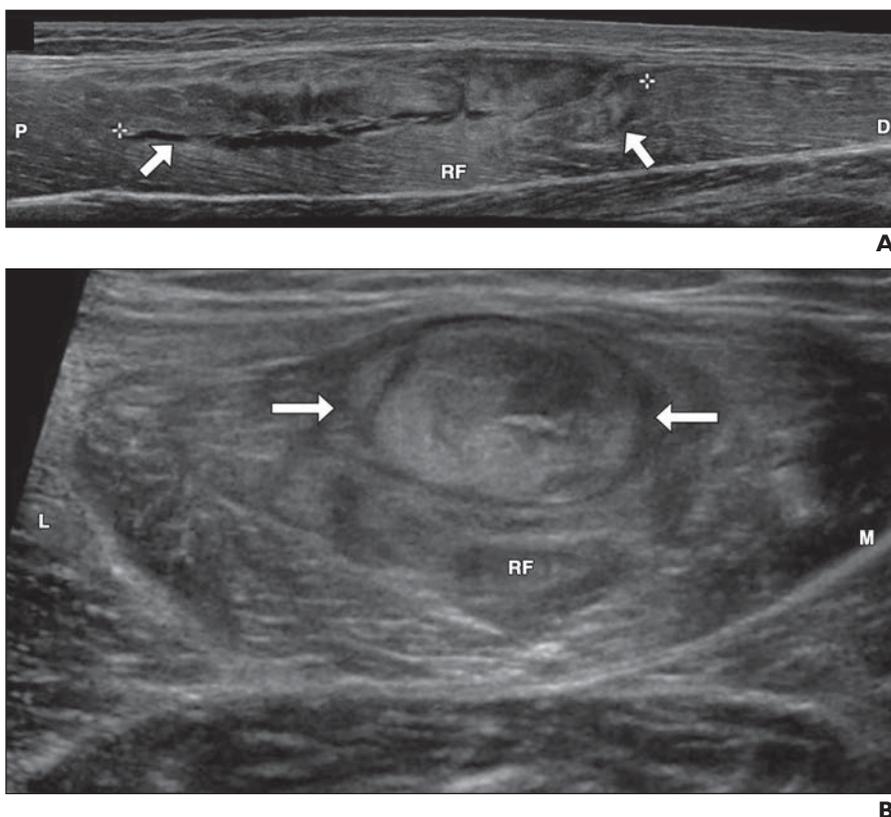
18-year-old woman with rectus femoris central tendon tear and palpable abnormality. A, Longitudinal extended FOV sonogram shows discontinuous rectus femoris (RF) fibers with fluid filling muscle defect (arrows). Calipers denote rectus femoris tear. D = distal, P = proximal. B, Transverse sonogram shows abnormal increased echogenicity around central tendon (arrows), described as bull's-eye appearance. L = lateral, M = medial.
